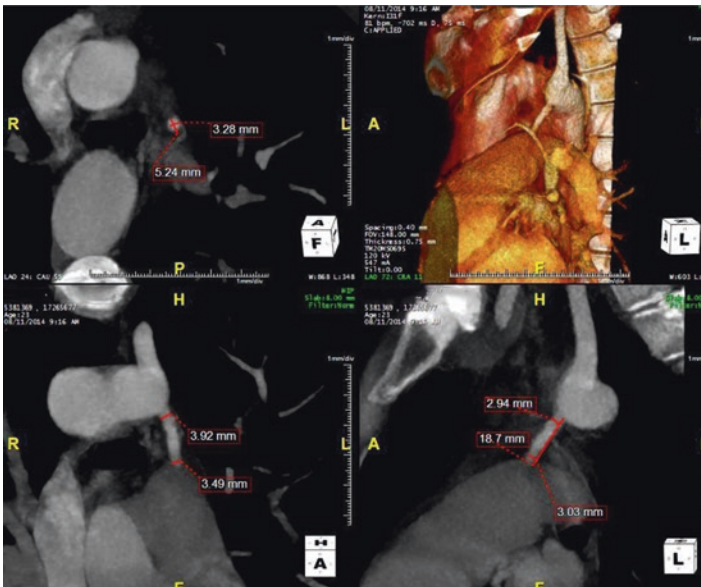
Cardiac CT can be useful to fully define the anatomy of a patent ductus arteriosus in preparation for surgical or percutaneous closure
